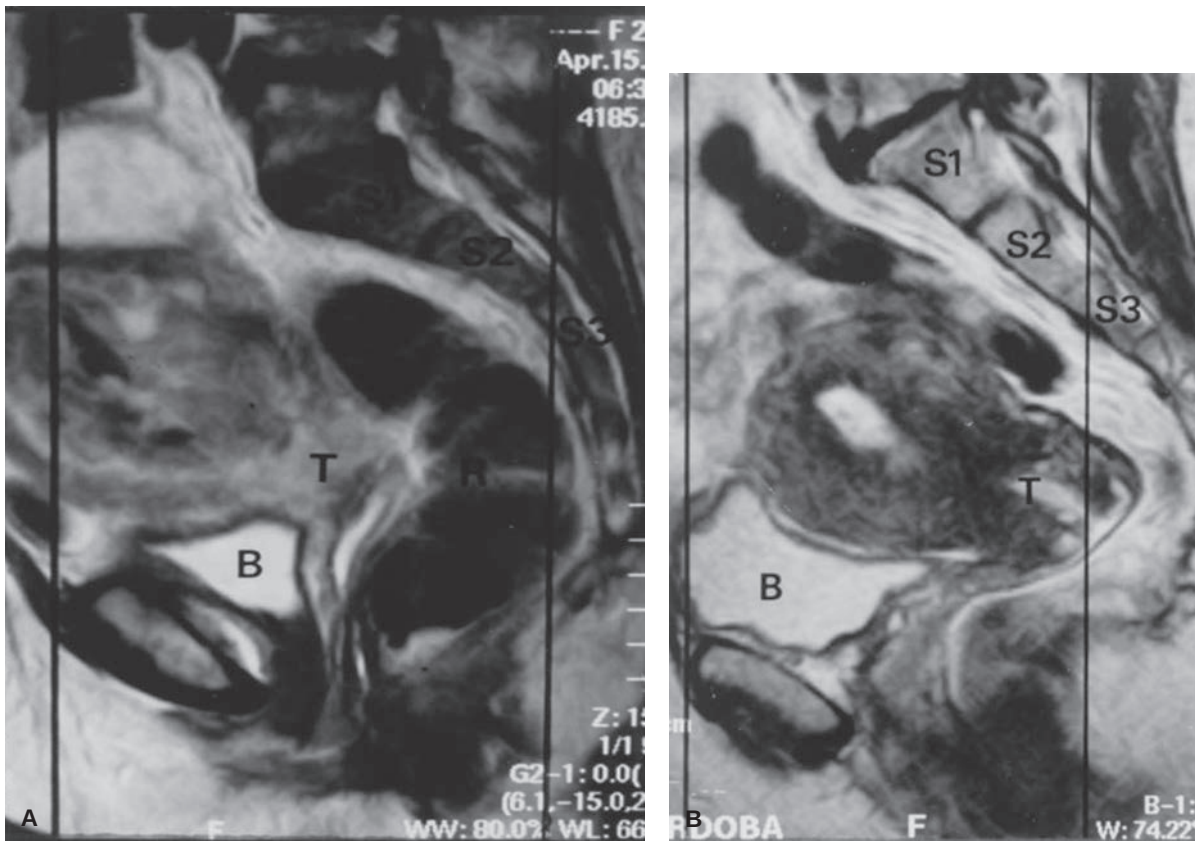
(A–B): Traditional lateral fields are superimposed on sagittal MRI scans to evaluate target coverage with traditional fields. Note in A: that the traditional lateral fields would not completely cover the uterine fundus, and that in B: the traditional lateral field would cut through cervical tumor within the anteverted uterus.
